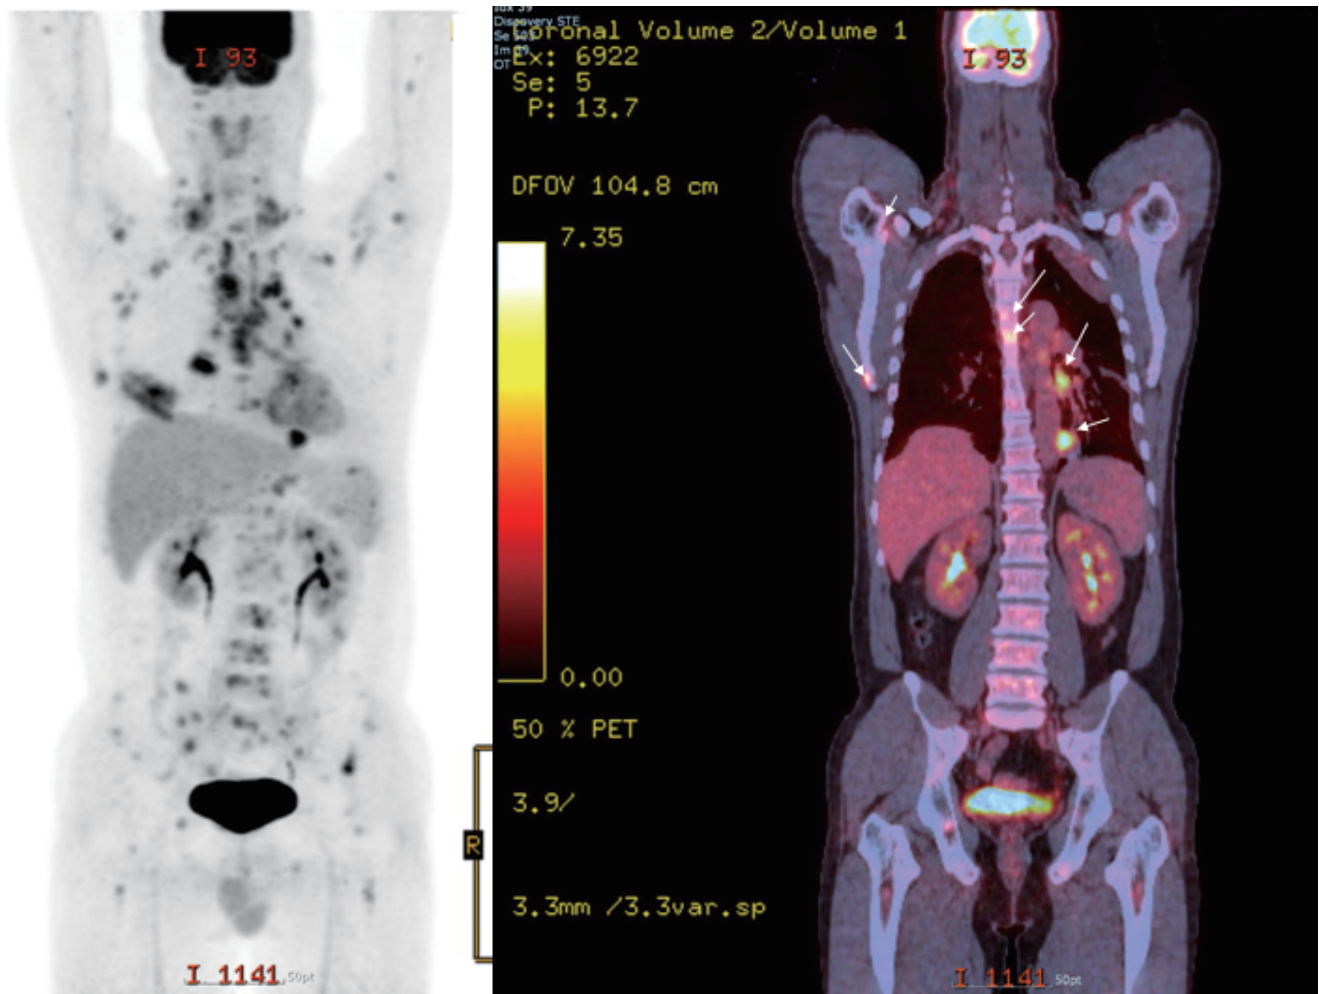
Functional metabolic flux imaging technology may help to detect cancer cells. 2-fluoro-2-deoxy-D-glucose (FDG)-PET/computed tomography in a 45-year-old male diagnosed with lung cancer. This demonstrates a hypermetabolic focuses (small arrows) in coronal PET-computerized tomography images. There are FDG-avid hypermetabolic nodules in the left lower lobe of lung and multiple FDG-avid bone lesions in thoracic, lumbar spines, right scapula, sacrum, and both femurs. Yellow and white colors in the positron emission tomogram indicate a typical high glycolysis rate of the cancer cells.
